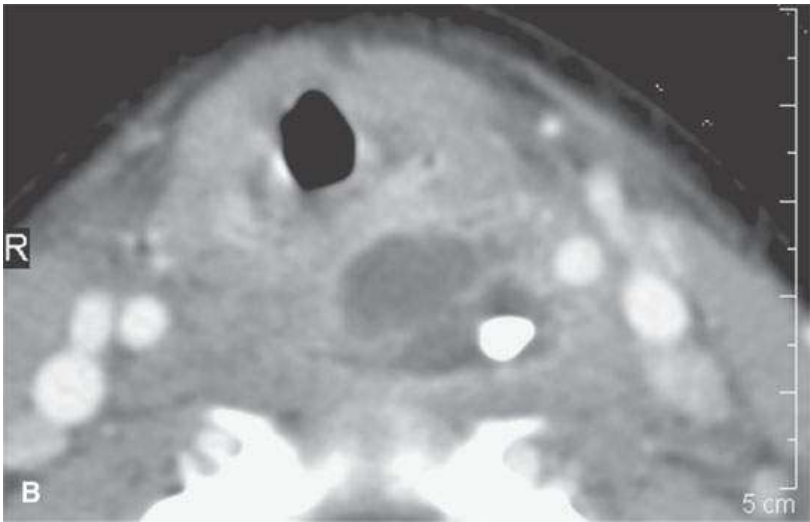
The calcified penetrating chicken bone fragment is seen both on the plain film (A) and in the middle of the abscess as seen on computed tomography (B). The diagnosis is much more straightforward than would be possible on magnetic resonance imaging.
